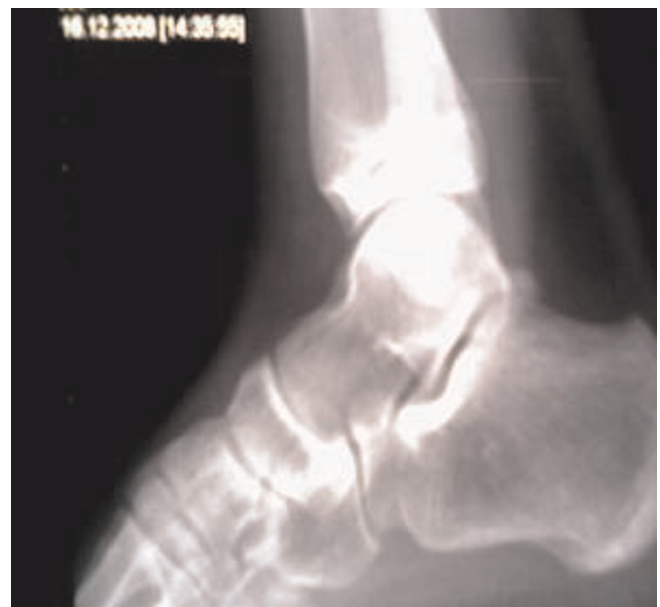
Lateral X-ray of the ankle after reduction.
